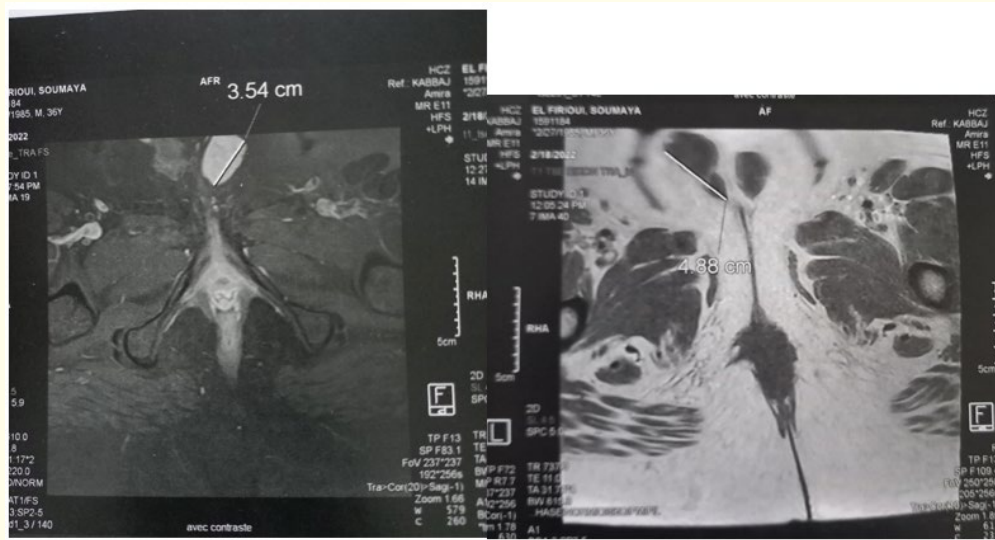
Pelvic MRI, the left formation measuring approximately 3.5 × 4.4 cm with homogeneously enhanced tissue signal.
